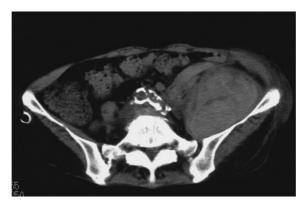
Abdominal computed tomography The abdominal aorta and bilateral iliac arteries showed severe circumferential calcification, and hematoma was observed around the left common iliac artery.
